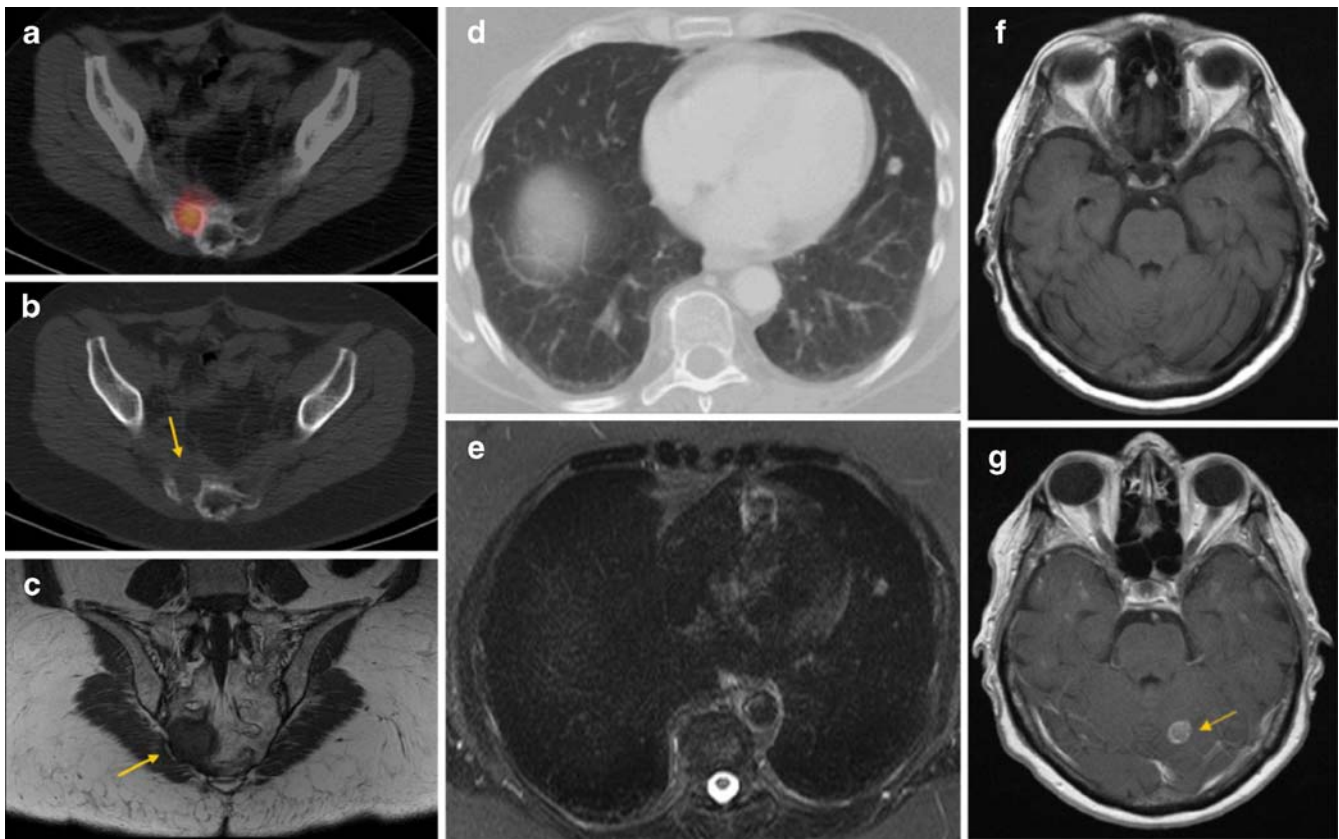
Whole-body MRI and FDG-PET-CT for the detection of distant metastases. a–c Bone metastasis in the right sacral bone with avid FDG uptake (SUV_{max} 7.5) in PET-CT and a visible osteolytic defect in MS-CT as well as corresponding hypointense bone lesion in coronal T1-weighted TSE-MRI (*arrows*). d,e Lung metastasis in a
